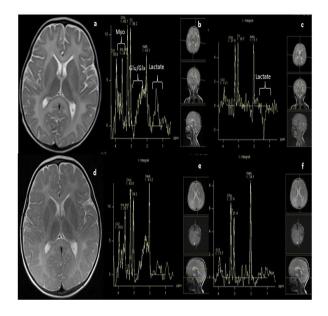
(a) Diffuse dysmyelination throughout supratentorial white matter during acute attack, short (b) and long echo MRS (c) shows increased myoinositol peak, increased glutamine/glutamate peak and increased lactate peak. (d) Controlled MRI and MRS performed one year later, decrease in T2 signal changes in supratentorial white matter, short (e) and long echo MRS (f) shows decrease in lactate and glutamine-glutamate peaks, unchanged myoinositol and choline peaks. Glu/Glx: Glutamine/glutamate. Myo:myoinositol
